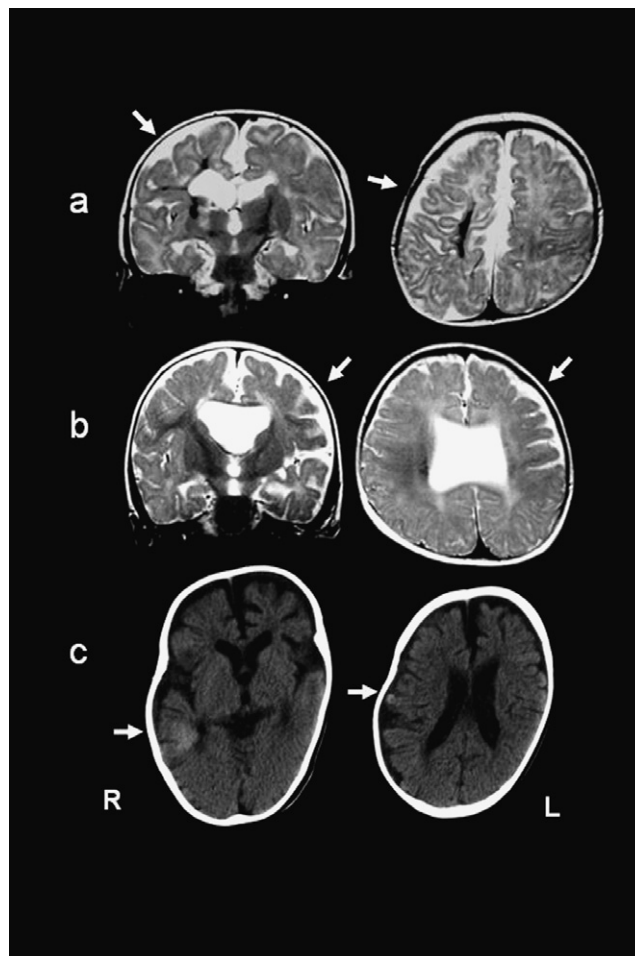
(a) MRI  $T_2$ -weighted images (TR, 2000 ms; TE, 80 ms) in patient 1; (b) MRI  $T_2$ -weighted images (TR, 2000 ms; TE, 80 ms) in patient 2; (c) CT in patient 3. The arrows show focal cerebral lesions. R, right; L, left.
